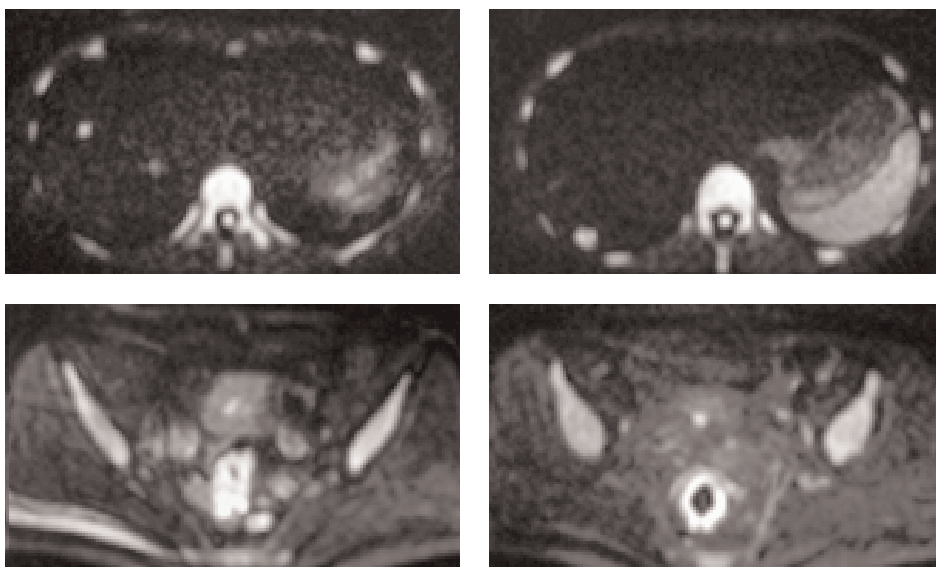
SPIO diffusion-weighted images – DWI (b = 1000)
